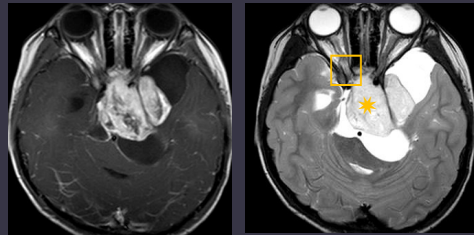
MRI T1 + C (Left) and T2 (Right)
